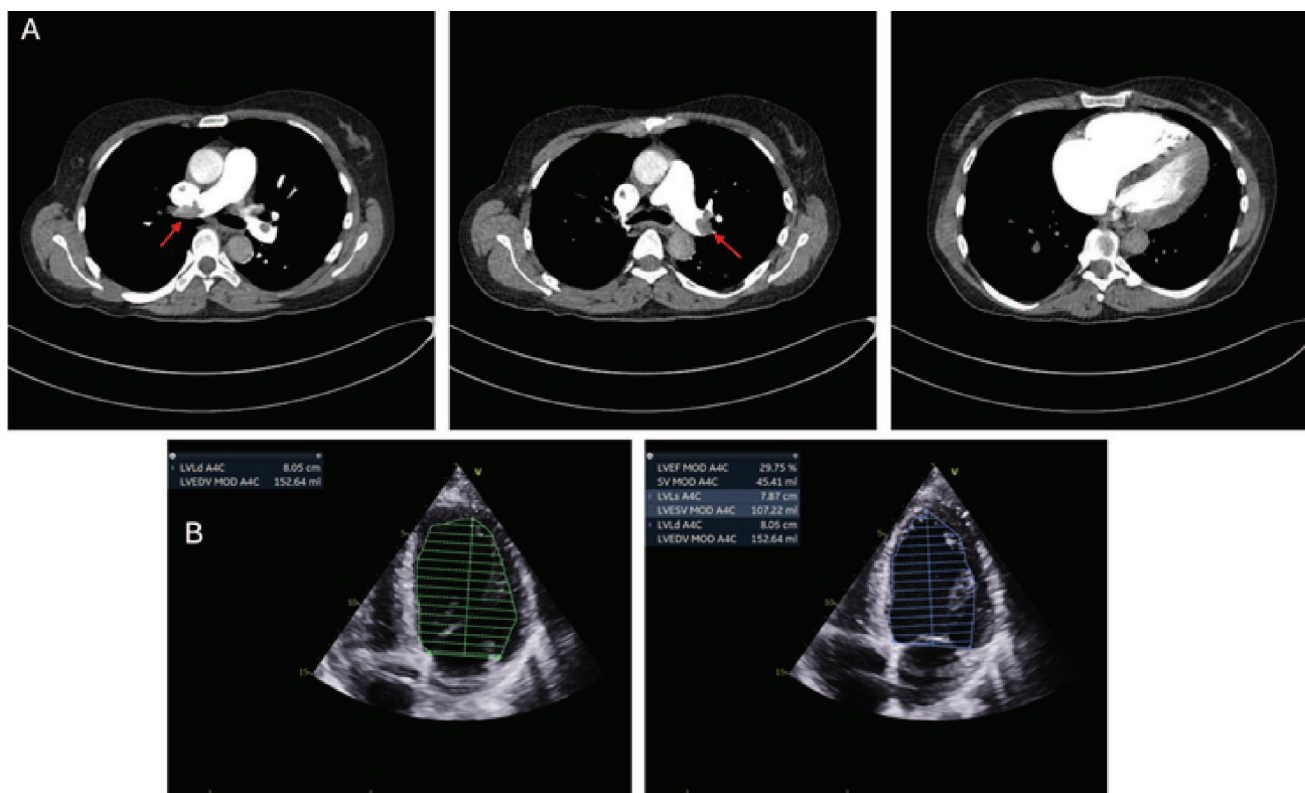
A) Multislice spiral computed tomography (MSCT) showing bilateral massive pulmonary embolism (red arrows) and a severely dilated right ventricle and atrium, with the interventricular septum shifted to the left. B) Ejection fraction calculation after admission.
